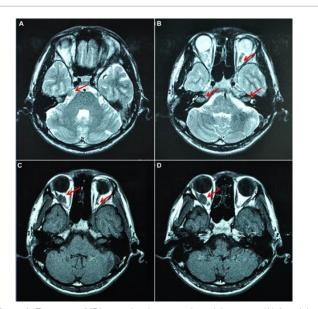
Transverse MRI scan showing several cranial masses. (A) A nodule is shown in the right trigeminal area. (B) A widened internal auditory canal tube suggests bilateral vestibular schwannomas. (C) A small tumor close to the left optic nerve is seen. (D) A fusiform mass in the lateral rectus of the right orbit compresses the neighboring optic nerve.
